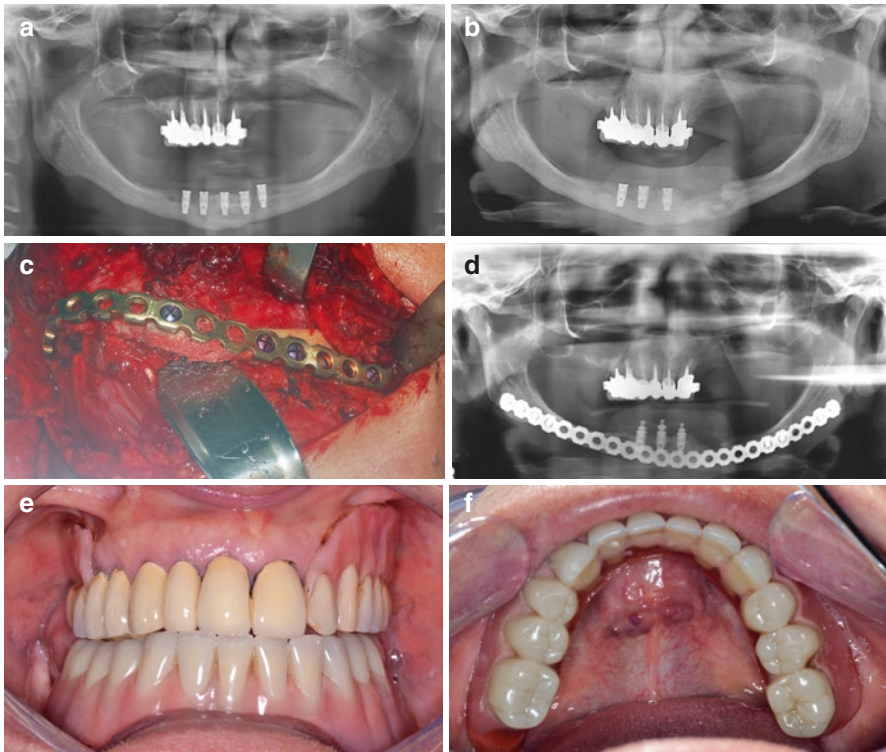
(a) Implants installed by guided surgery. (b) Fracture of the mandible after spontaneous loss of two implants. (c) Mandibular reconstruction with autogenous anterior iliac crest block bone graft and a locking mandibular reconstruction plate. (d) Postoperative radiograph after 6 months. O-ring abutments in place over the remaining implants. (e) Patient rehabilitated with an overdenture. (f) Inferior prosthesis adaptation
